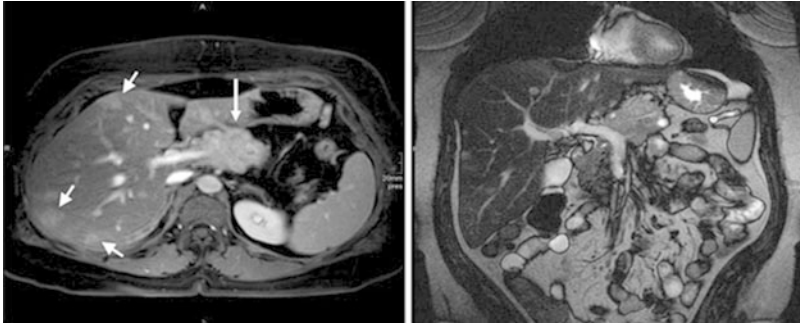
Enhanced computed tomographic scan demonstrates a large pancreatic gastrinoma (*large arrow*) with diffuse liver metastases (*arrowheads*)
